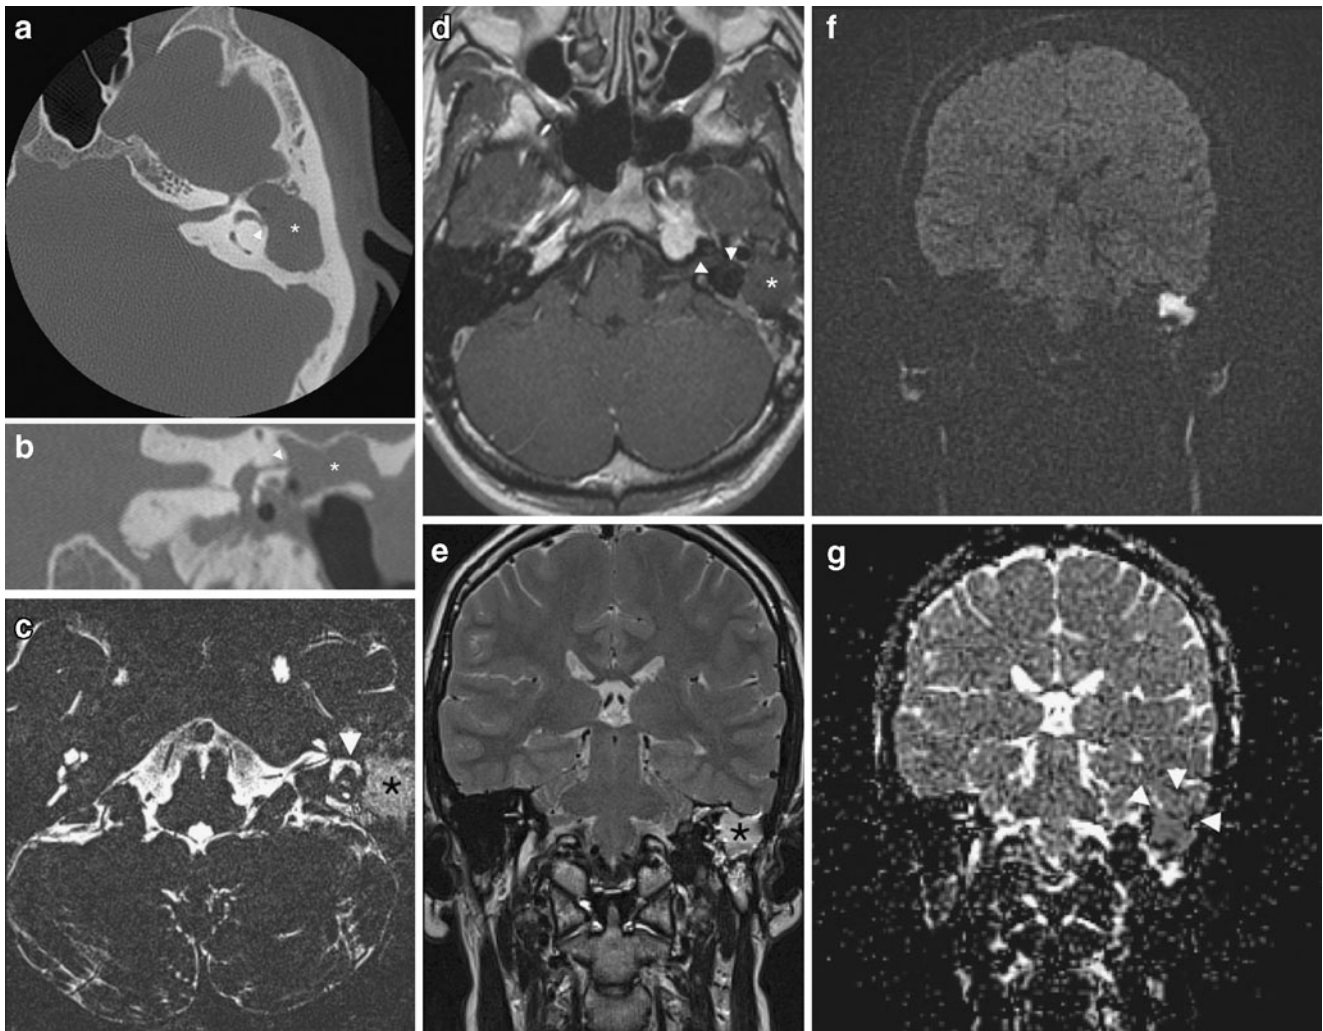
A 28-year-old male presenting with acute onset of vertigo. a Axial CT scan at the level of the lateral semicircular canal. There is a homogeneous opacification of the left middle ear and mastoid (*asterisk*) without further discrimination of any residual ossicles or bony trabeculation. There is a possible defect in the bony wall of the lateral semicircular canal (*arrowhead*). b Coronal CT reformation at the level of the intersection of the superior semicircular canal, the lateral semicircular canal, and the vestibule. Soft tissues (*asterisk*) in the middle ear and mastoid with possible fistulisation towards the lateral semicircular canal (*arrowhead*). c Axial 0.4-mm-thick 3D TSE T2-weighted image at the level of the lateral semicircular canal. The entire middle ear is filled with a moderate intense nodular lesion (*asterisk*). Signal intensities in the membranous labyrinth and at the level of the lateral semicircular canal more specifically are normal (*arrowhead*). d Axial delayed post-gadolinium 2-mm-thick SE T1-weighted image at the level of the lateral semicircular canal. There is a centrally non-enhancing lesion in the middle ear and mastoid
